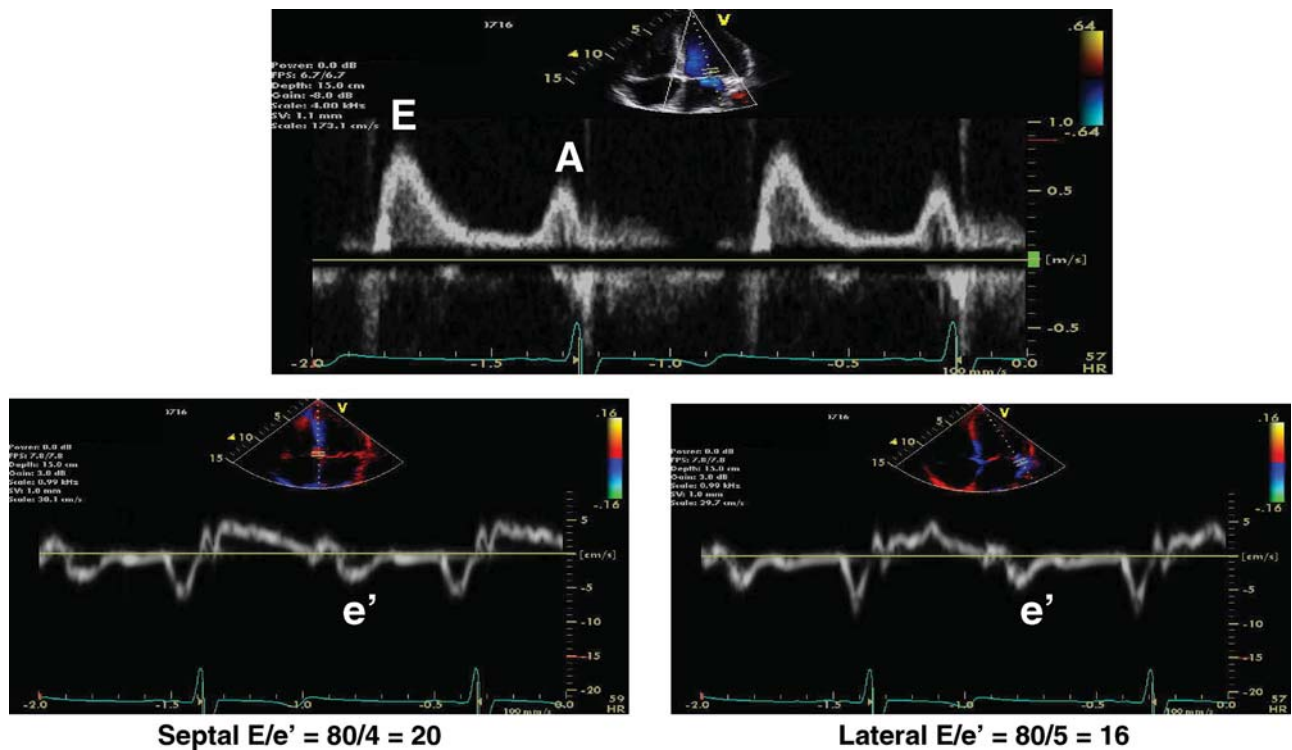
Mitral inflow (*top*), septal (*bottom left*), and lateral (*bottom right*) tissue Doppler signals from a 60-year-old patient with heart failure and normal EF. The E/é ratio was markedly increased, using é from either side of the annulus.
